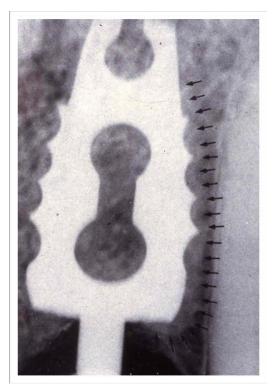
radiographic enlargement to highlight the formation of a "lamina dura" (arrows) around the implant.
